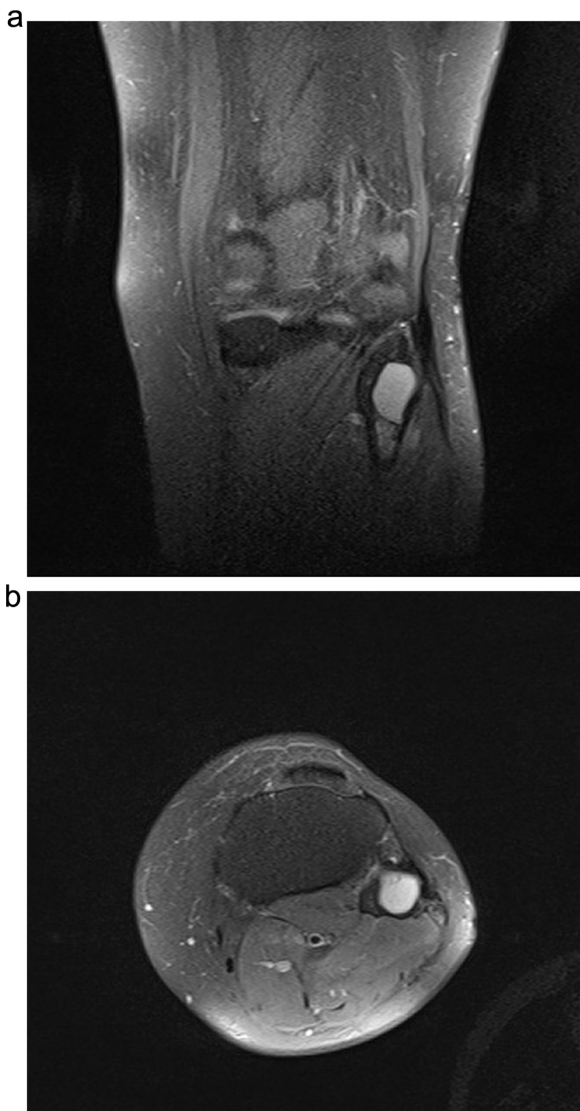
a: Coronal view of the ganglion cyst on T2 weighted MRI. b: axial view of the ganglion cyst on T2 weighted MRI.
